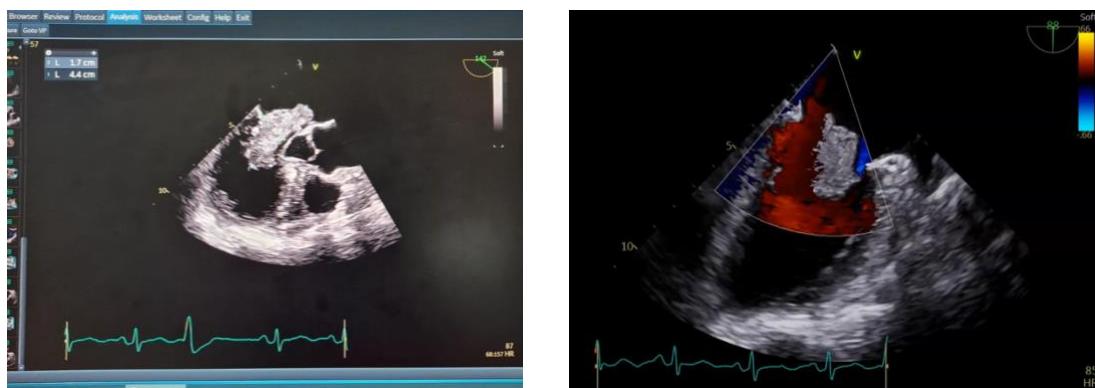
Echocardiography showing mass in the Left atrium (arrow)
